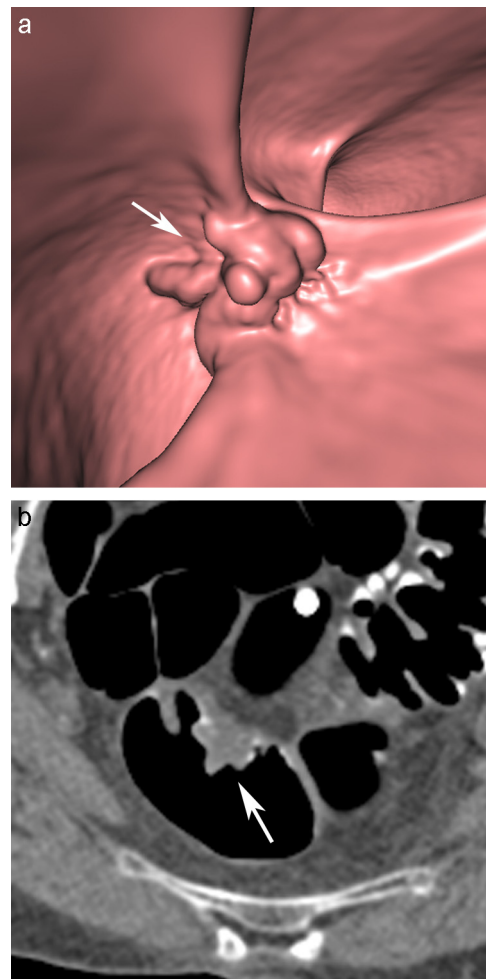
23 mm advanced adenoma in the sigmoid colon. (a) 3D endoluminal CT image shows a sessile, broad-based lobulated filling defect (arrow). (b) Prone 2D axial CT image shows a homogeneous soft tissue attenuation of the intraluminal filling defect (arrow).
